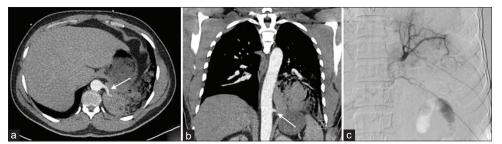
A 34-year-old male who presented with large volume hemoptysis. Axial (a) and coronal (b) arterial phase CT demonstrating a large single vessel off the descending thoracic aorta supplying the left lower lobe (arrows). (c) Digital subtraction angiogram demonstrating the aberrant arterial feeding vessel off the thoracic aorta.
